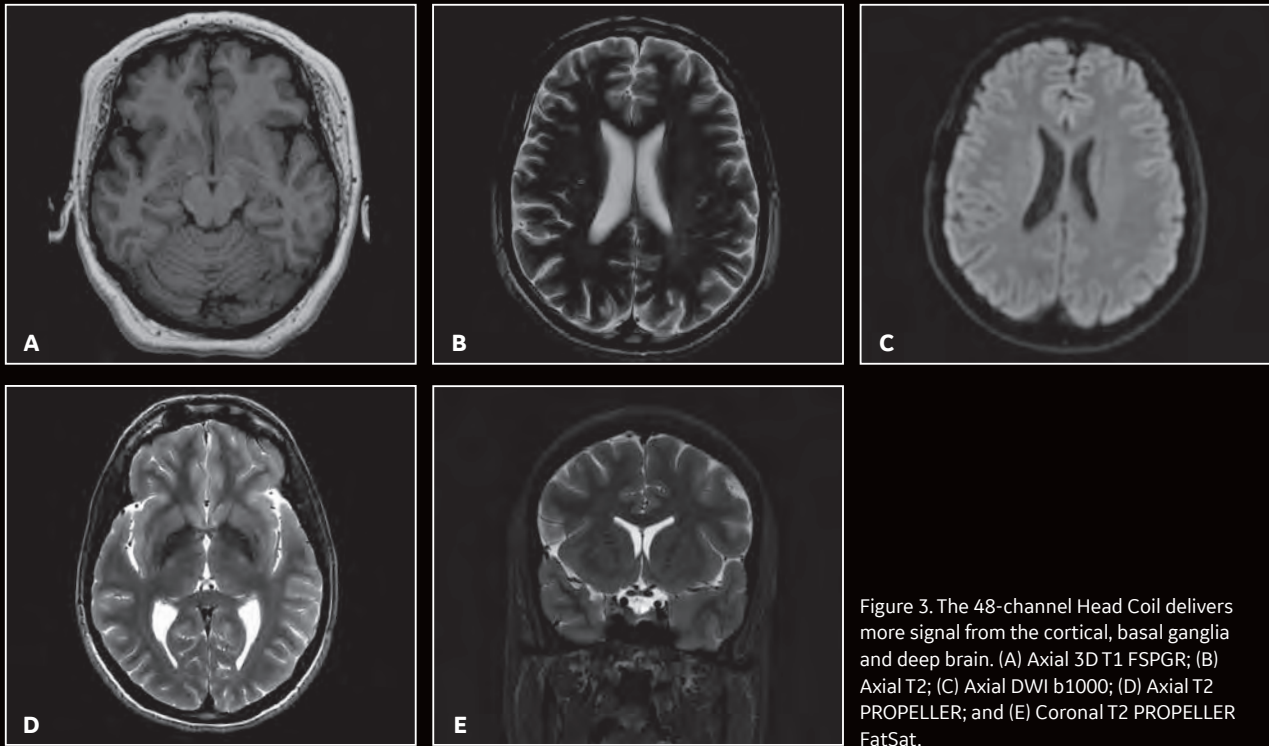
The 48-channel Head Coil delivers more signal from the cortical, basal ganglia and deep brain. (A) Axial 3D T1 FSPGR; (B) Axial T2; (C) Axial DWI b1000; (D) Axial T2 PROPELLER; and (E) Coronal T2 PROPELLER FatSat.
